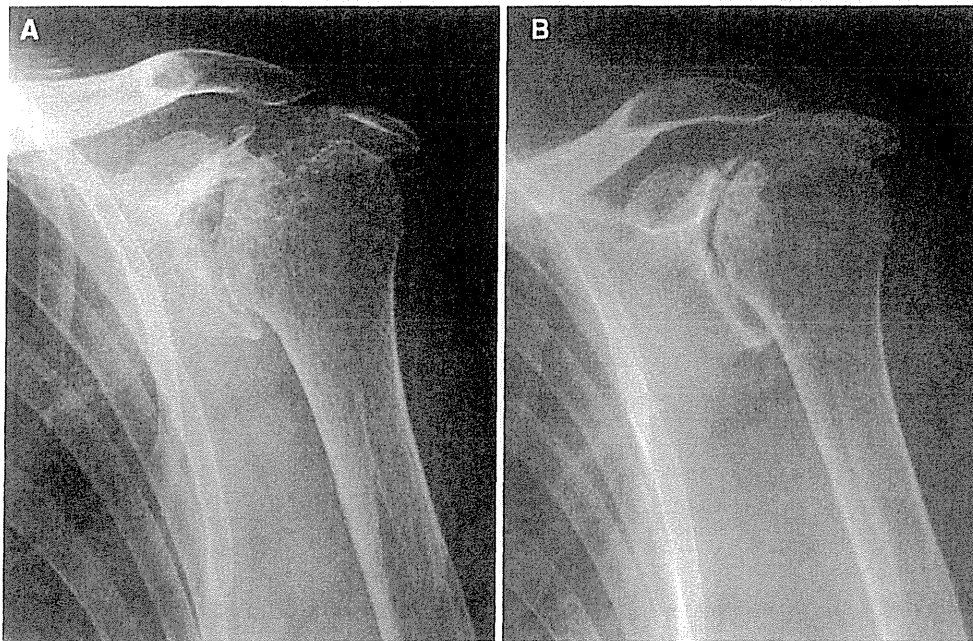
Anteroposterior radiographic view of left shoulder joint at baseline (a) and at final follow up (b) after 4 years of treatment with etanercept (25 mg SC 2/week) in combination with methotrexate (6 mg/week)
